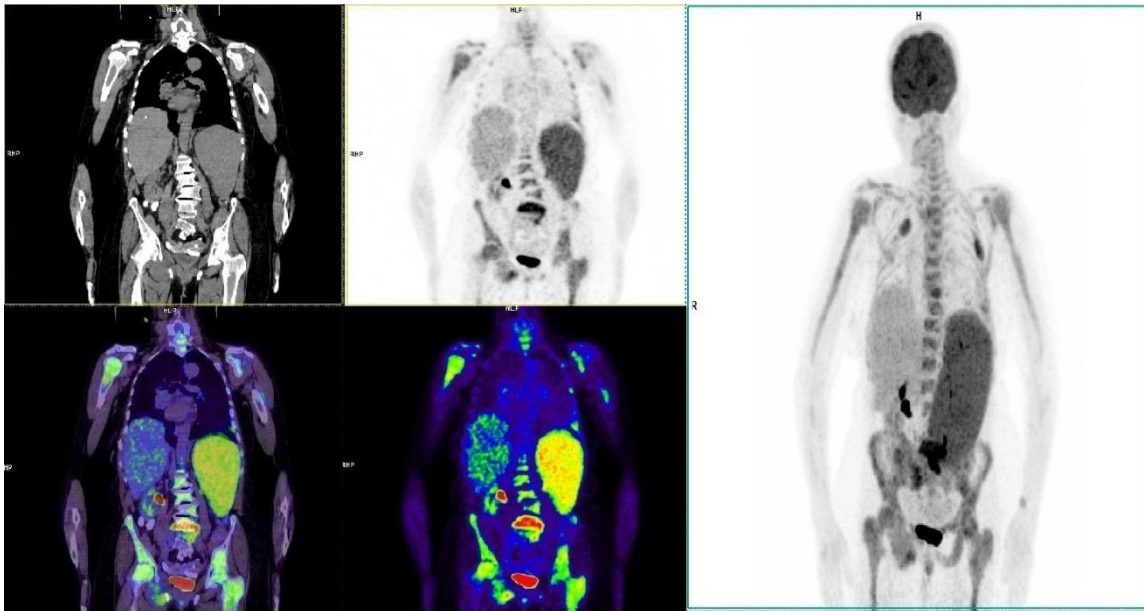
FDG uptake of tumor tissue in the skeletal system, spleen, bilateral pleura, and the lesion adjacent to L5 vertebra anterior in the coronal plane and MIP images observed in 18F-Fluorodeoxyglucose (FDG) positron emission tomography (PET) / computed tomography (CT)
